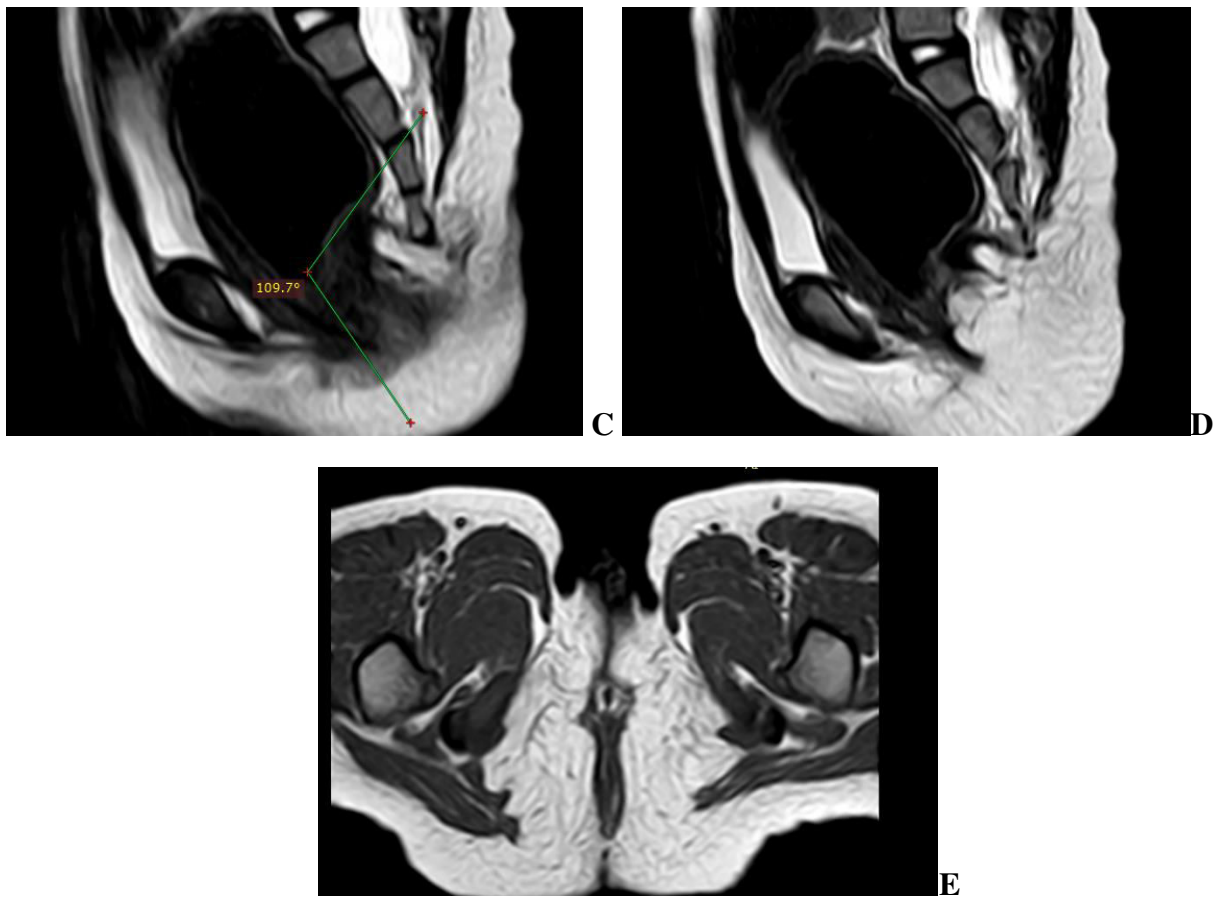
Pre-Operative Pelvic MRI, T2WI (Mid sagittal plane) A: show increased anorectal angle+/-111.5° indicated anterior ectopic anus. B: show anterior displacement of distal anal canal in front of muscle (arrow) and mild dilation of the rectum. Post-Operative Pelvic MRI, T2WI (Mid sagittal plane) C: show mild increase of anorectal angle+/-107°. D: collapsed rectum. E: T2WI (coronal plane) shows asymmetrical thickness of sphincter muscle (fair developed sphincter).
